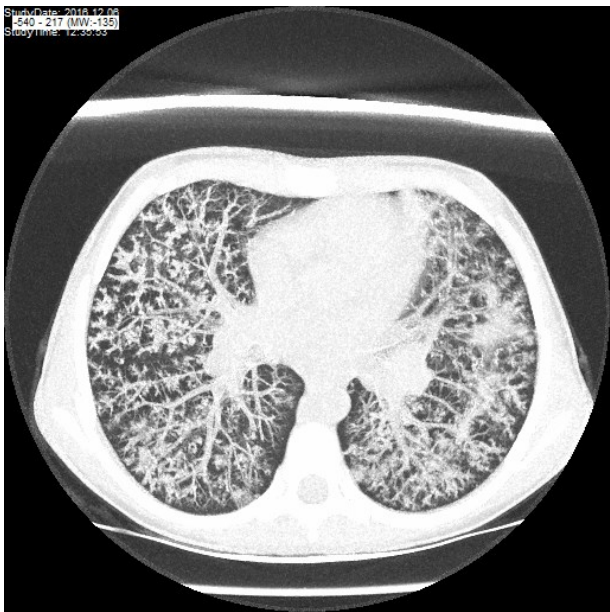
CT scan of the lung of J.M. from the 12/06/2016 showing typical tree-in-a-bud structure
